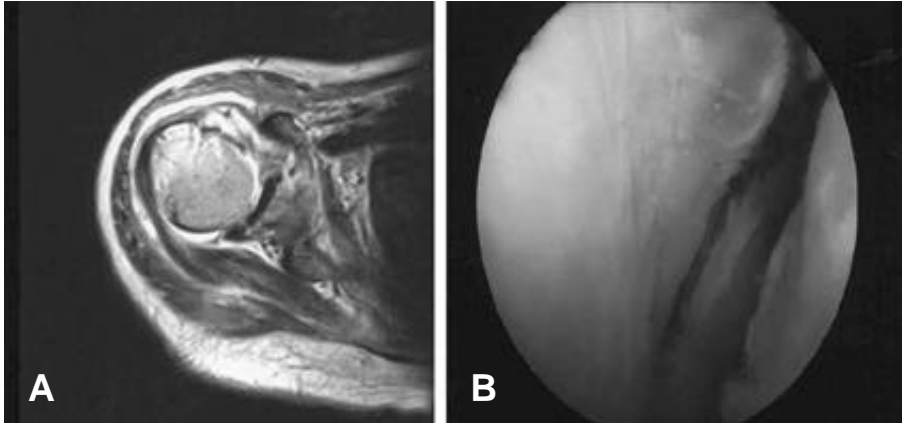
A 43 years old patient with a septic shoulder. An axial T2-weighted image demonstrates fluid outpouching. The anterior capsule is irregular and thick with irregular margin(A). Yellow cheese like fibrotic tissue over the synovium at anteroinferior quadrant of the joint(B).
